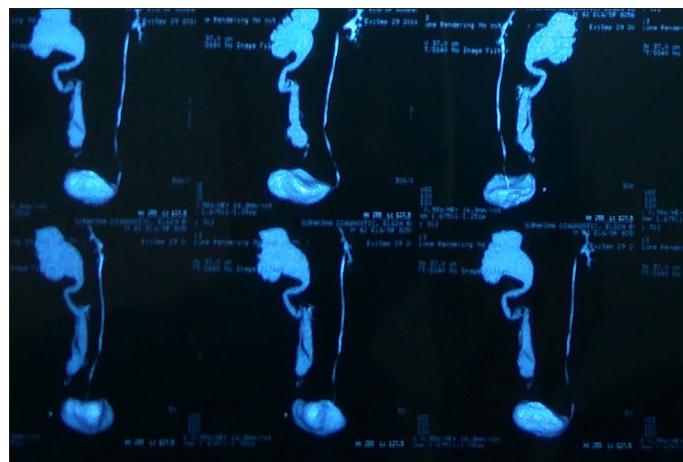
Contrast-enhanced computed tomogram of the abdomen showing dilated right renal pelvis, tortuous dilated ureter with abrupt narrowing in the lower one-third of the ureter
